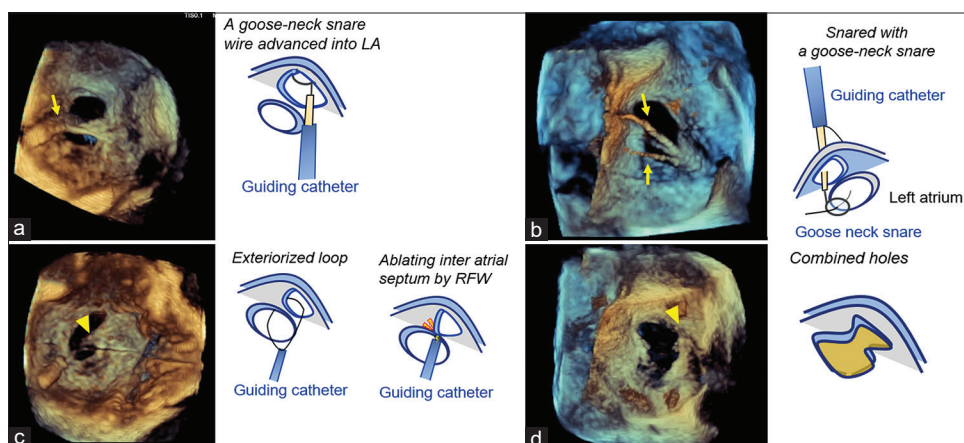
(a) Real time three-dimensional transesophageal echocardiography image confirming that a 7 mm-diameter goose-neck snare wire advanced into the left atrium via the superior atrial septal defect. (b) A 0.010-inch soft wire (arrows) has been inserted via the inferior atrial septal defect. (c) The tip of a 0.010-inch wire has been snared then pulled back into the guiding catheter to make an exteriorized loop (arrow head). Radiofrequency energy-assisted wire atrial septostomy was performed. (d) A large single defect was successfully made
